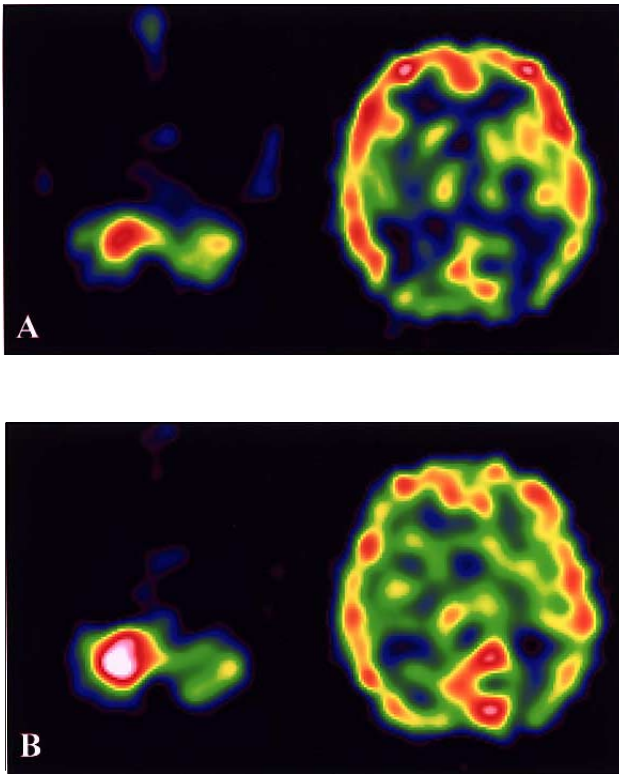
N*-Isopropyl-*p*-[¹²³I]-iodoamphetamine (¹²³I-IMP) SPECT immediately after biopsy. A: Early SPECT images show increased accumulations of ¹²³I-IMP in the right cerebellum and left occipital lobe. B: Delayed SPECT images show high retention of the tracer in the right cerebellum and left occipital lobe. The ¹²³I-IMP defect and decreased accumulation in the left parieto-occipital region are indicative of postoperative changes.
